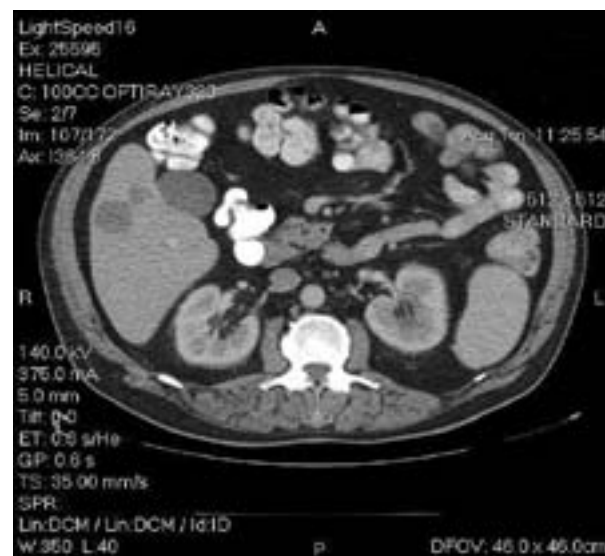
CT image showing multiple low density lesions in the liver.
